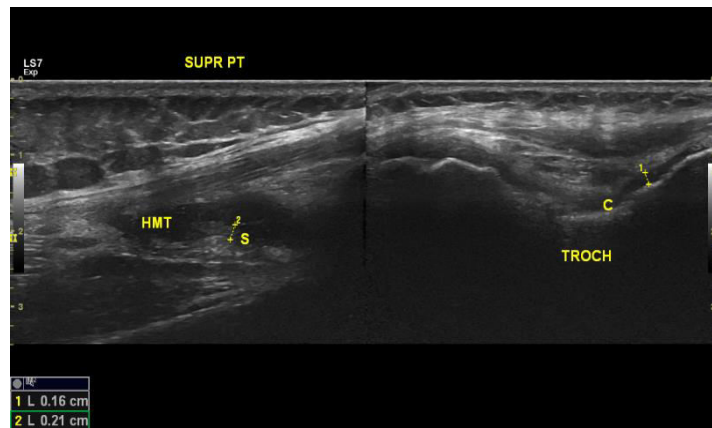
Sample image from ultrasound scanning during the study. Suprapatellar sagittal view [L1 anterior sagittal central view]. Shows suprapatellar bursa hematoma.
